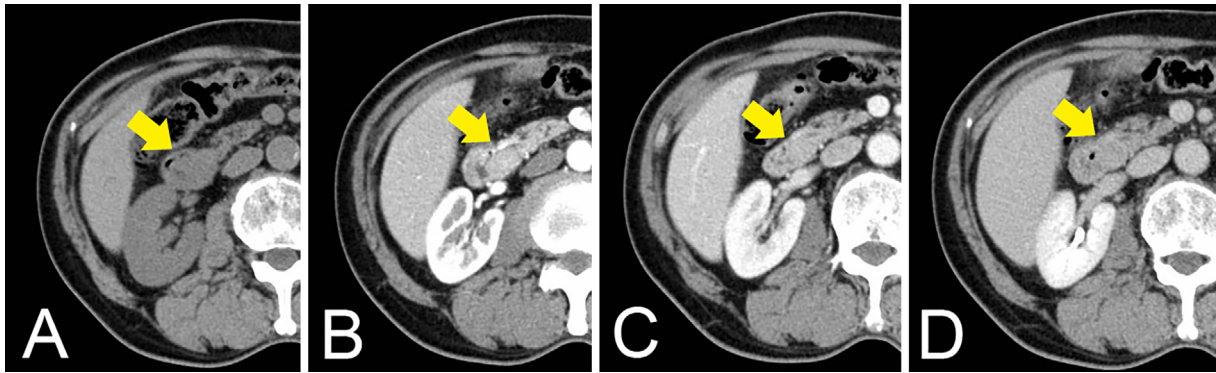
Computed tomography (CT) showed contrast-enhanced mucosal hypertrophy from the duodenal papilla to the distal bile duct (yellow arrow: A, plain; B, arterial phase; C, portal phase; D, equilibrium phase). The hypertrophy was enhanced in (B) the arterial phase, and (D) the enhancement was washed out in the equilibrium phase.
